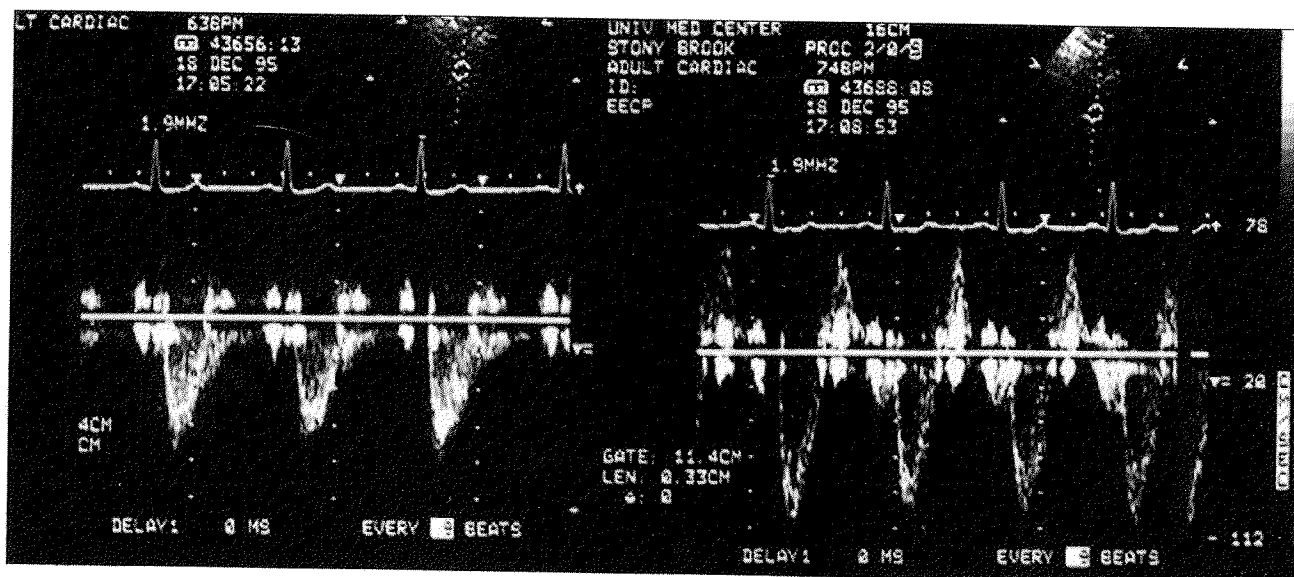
Retrograde flow in the descending aorta during diastole is seen in the pulsed wave Doppler echocardiogram on the right, obtained during enhanced external counterpulsation (EECP). The left panel is a control echocardiogram of the descending aorta in the same patient just before activation of the EECP system. The right panel shows that the antegrade systolic stroke distance is increased during EECP, reflecting increased cardiac output.
